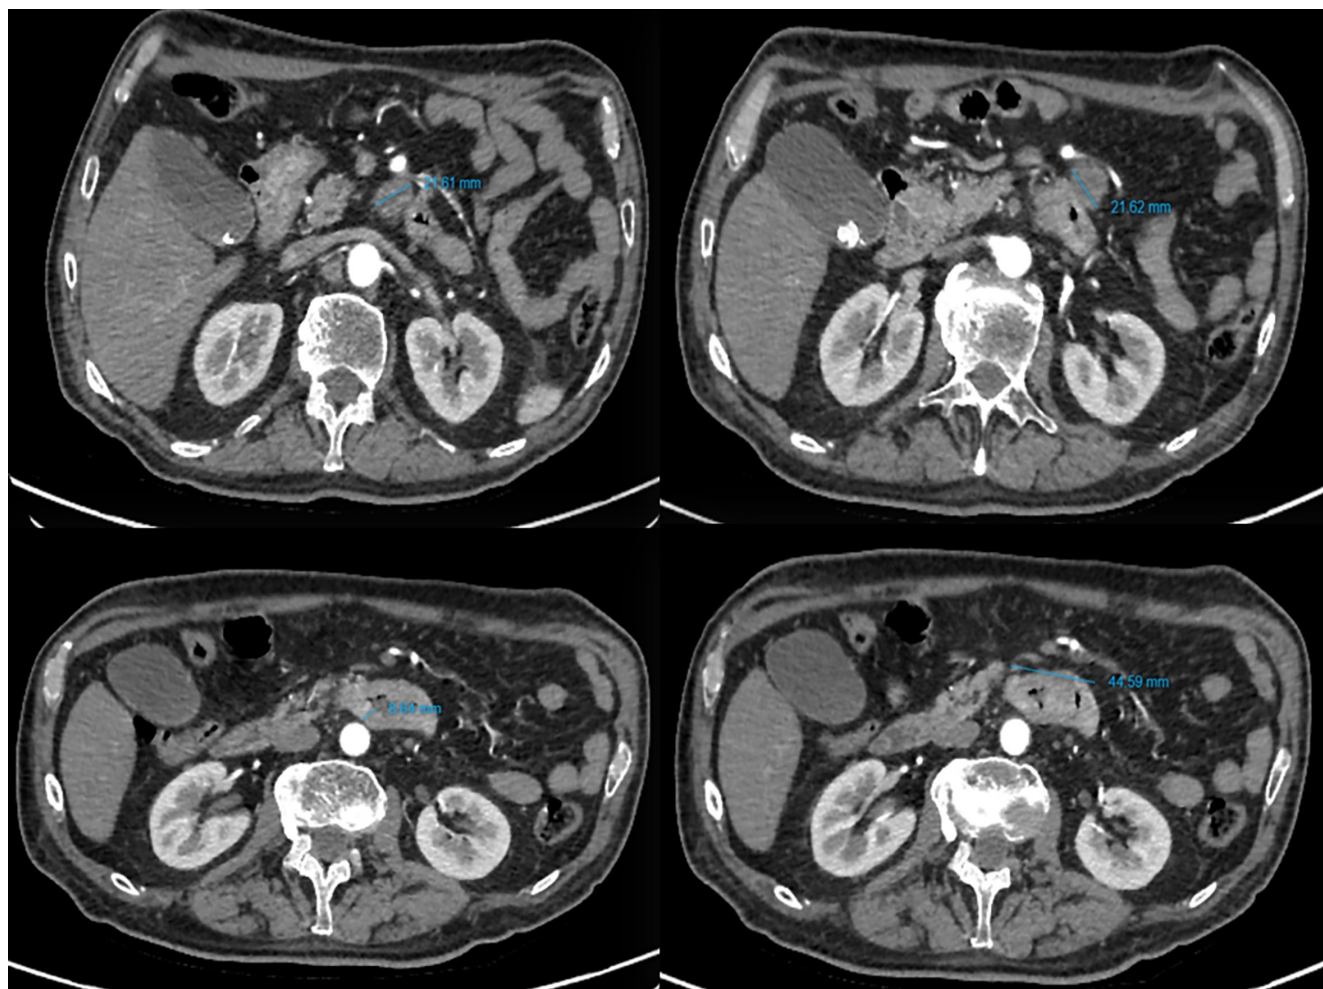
Contrast-enhanced computed tomography of the abdomen and pelvis reporting an irregular thickening of the walls in the third portion of the duodenum, adjacent mesenteric lymphadenopathy, cholelithiasis, atherosclerosis of the aorta, and an enlarged prostate. Source: Radiology Service, Hospital Internacional de Colombia. Selected by the authors.
